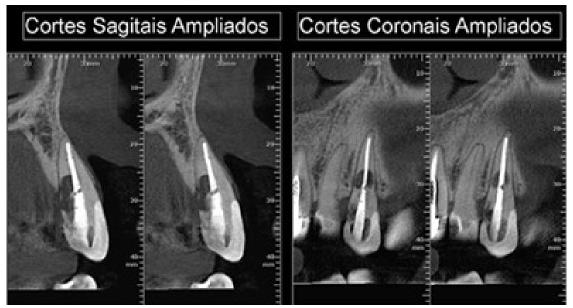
Initial Cone-Beam Computed Tomography (CBCT) with OP300 Instrumentarium[®]. Bone loss is noted following the extent of the lesion invaginating into the root canal
